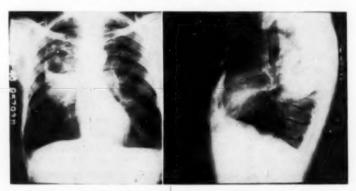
Roentgenogram suggests lung abscess but tumor cell found in bronchoscopic aspiration.
